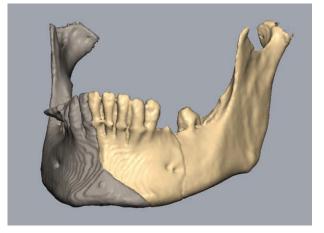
Imaging and final outcome. A-B, Different views showing the 3D reconstruction of the preoperative CT. C-D, Postoperative CT showing the proper reduction and fixation. E-F, Clinical postoperative photographs showing a good aesthetic result.
